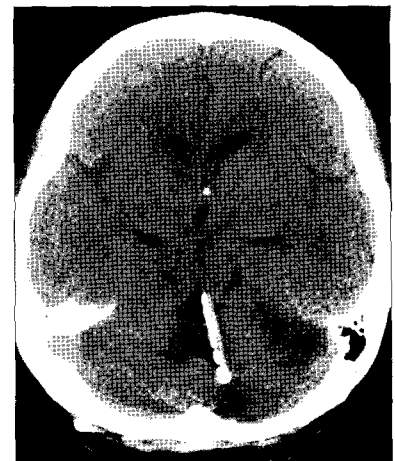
Computed tomography scan obtained 6 month after surgery shows marked reduction in size of the fourth ventricle.
